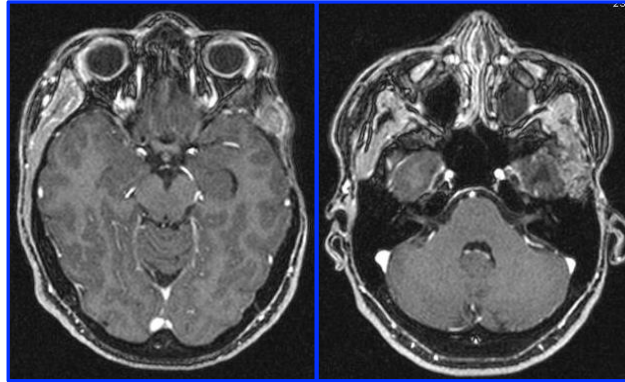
Brain MRI: Axial view, coronal and sagittal reformat of post-contrast T1 VIBE sequence, showing the high enhancement of the pathological tissue at the level of surgical outcomes.
